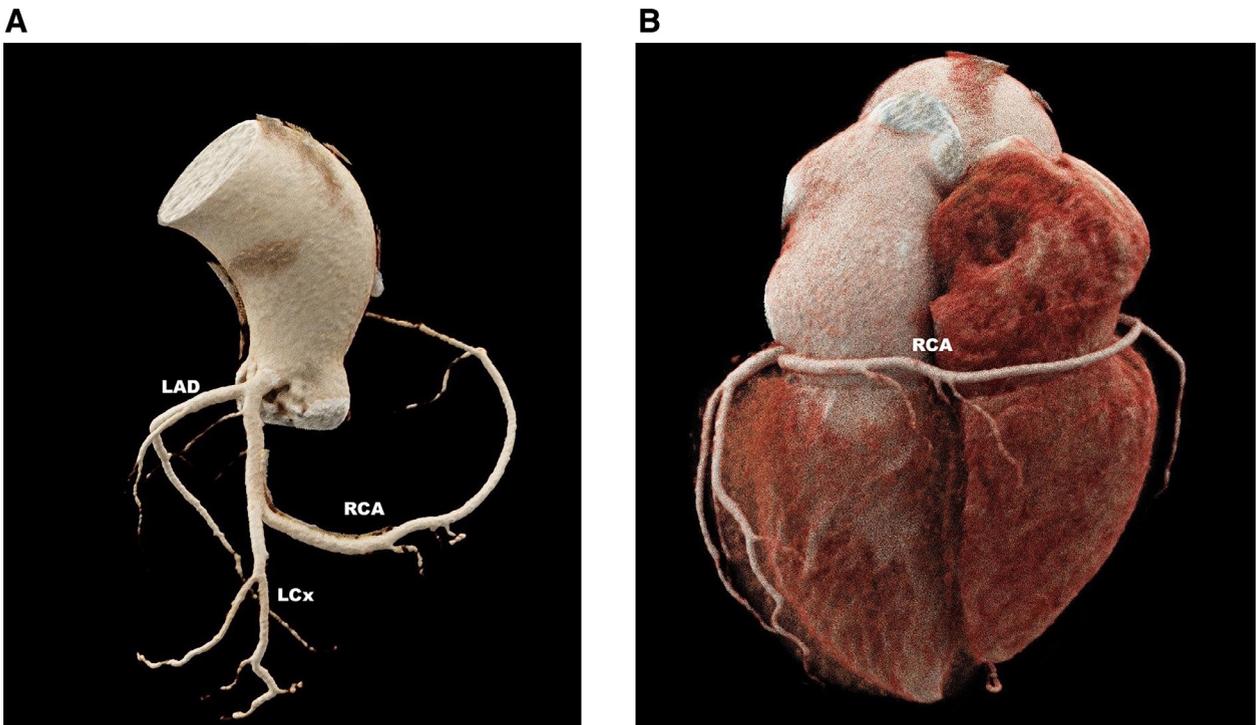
Single coronary artery (SCA) type Lipton L1. Coronary computed tomography, volume-rendered reconstruction (A) Lateral view, image shows a SCA originating from the left sinus of Valsalva. (B) Posterior view shows the right coronary artery taking-off from the left circumflex coronary artery. LAD = left anterior descending artery; LCx = left circumflex artery; RCA = right coronary artery.
